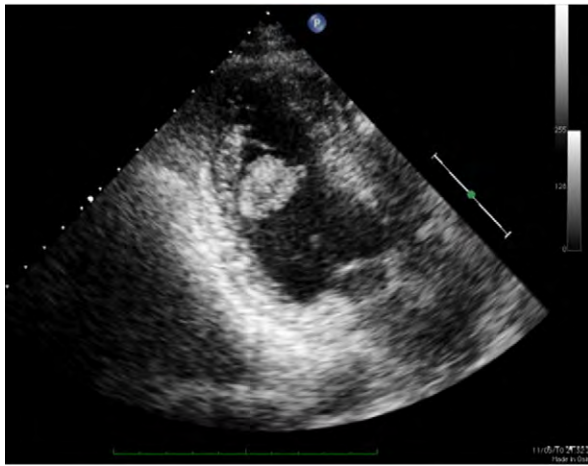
Transthoracic echocardiogram (3-chamber view) reveals the tumor in the left ventricular cavity.
